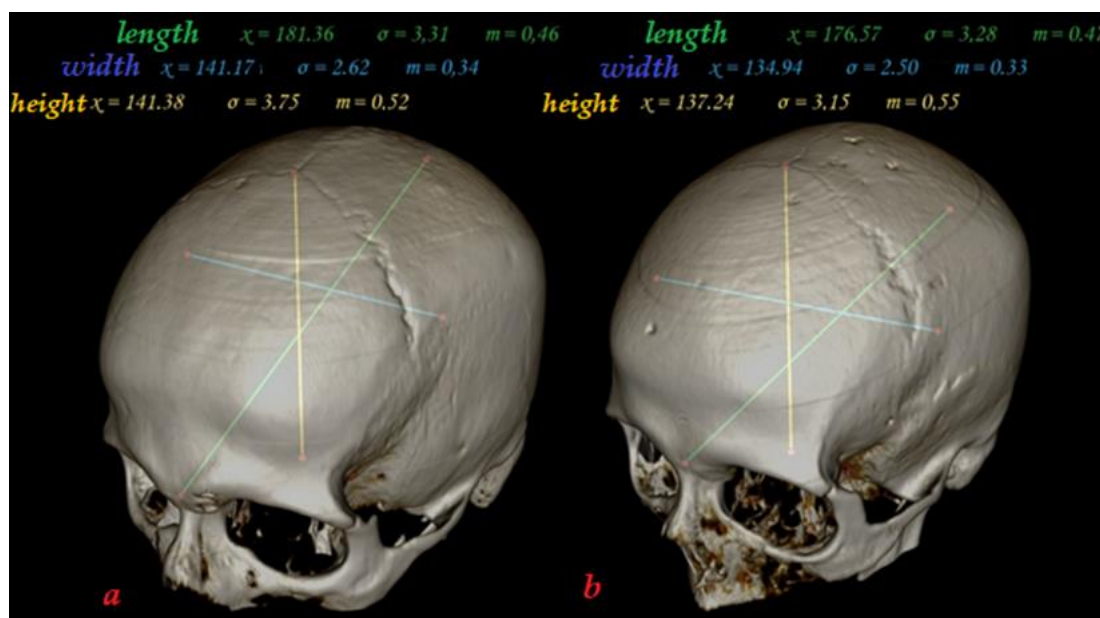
Gender characteristics of the main linear dimensions of the skull of a mature person: a – male. b – female (CT No.1875-16; CT No.957-16)
